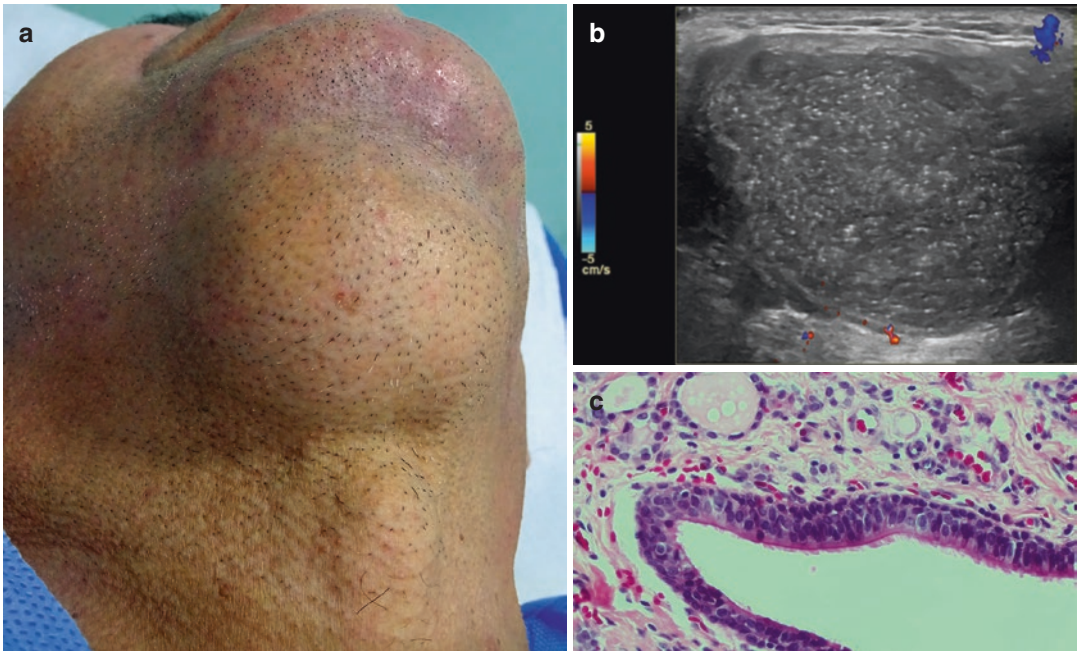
Thyroglossal cyst. (a) Clinical image of the anterior neck. (b) Color Doppler ultrasound (transverse view; anterior neck) shows oval-shaped well-defined subaponeurotic hypoechoic structure with some bright echoes
